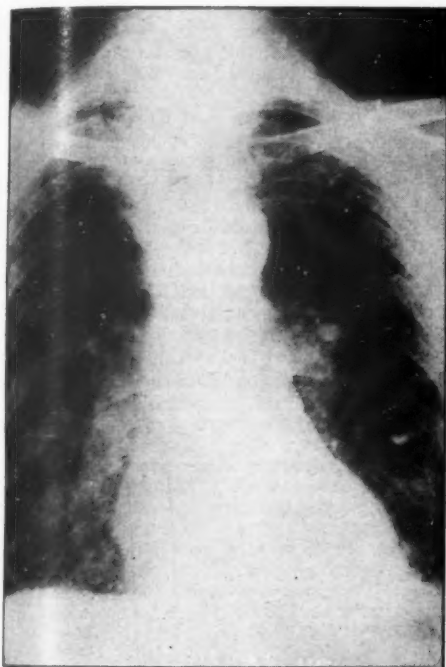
Chest X-ray (12.2.54) showing diffuse reticulation with many small "cysts" up to 5 mm. diameter.
